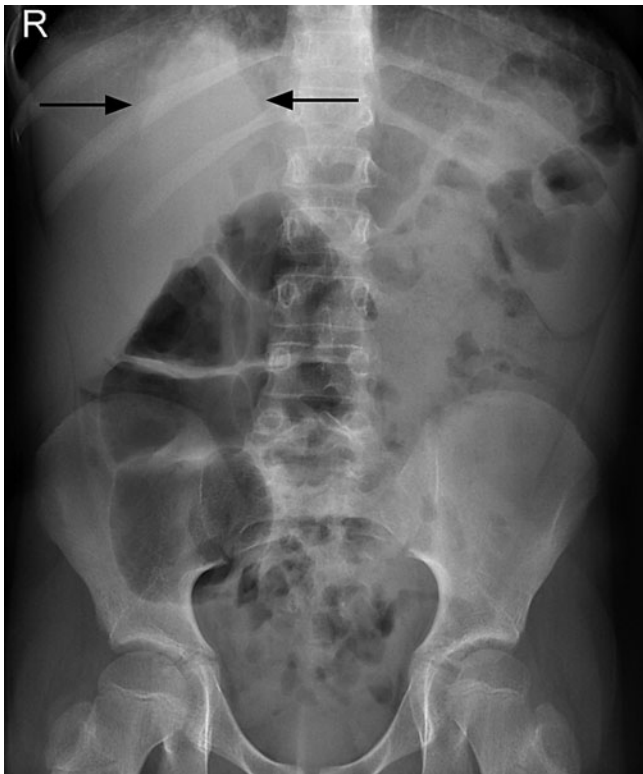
Young boy who presented with right-sided abdominal pain and fever. The supine abdominal radiograph shows a triangular area of density at the right lung base (*arrows*), consistent with right lower-lobe pneumonia, the cause of referred pain into the abdomen
